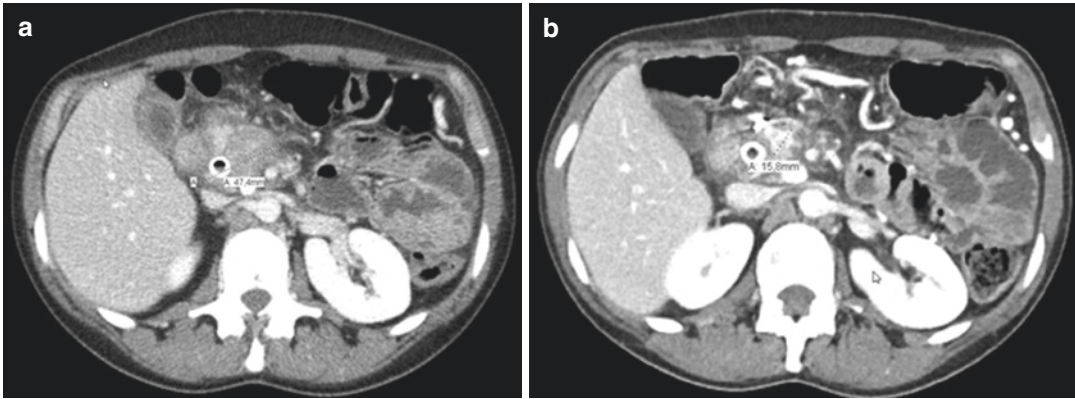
(a) Baseline CT scan with pancreatic tumor of 4.7 cm. (b) CT scan with pancreatic tumor shrunk to 1.6 cm after 8 cycles of FOLFIRINOX and 40 Gray of SBRT
